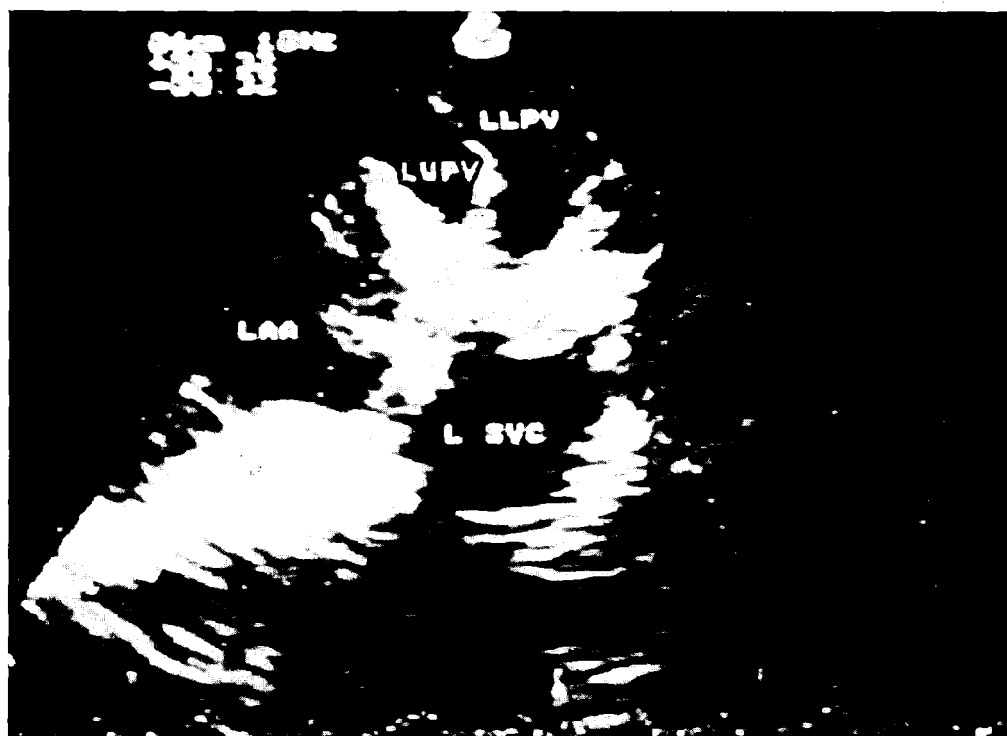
Transesophageal demonstration of a left persistent superior caval vein (L SVC), which connected to the coronary sinus. The vessel is found interposed between the left atrial appendage (LAA) and the left upper pulmonary vein (LUPV).
